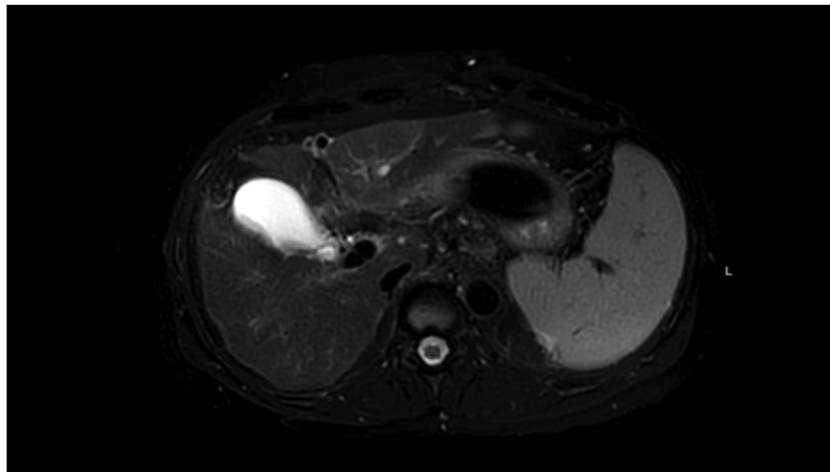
MRI at the 3-month follow-up revealed complete resolution of the lesion in the caudate lobe without any fresh lesion in the liver.
